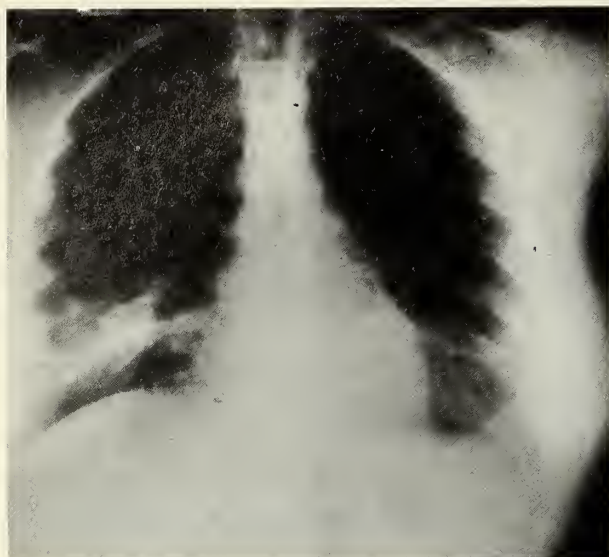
PA and lateral chest x-rays of the patient on admission showing a right middle lobe infiltrate.
